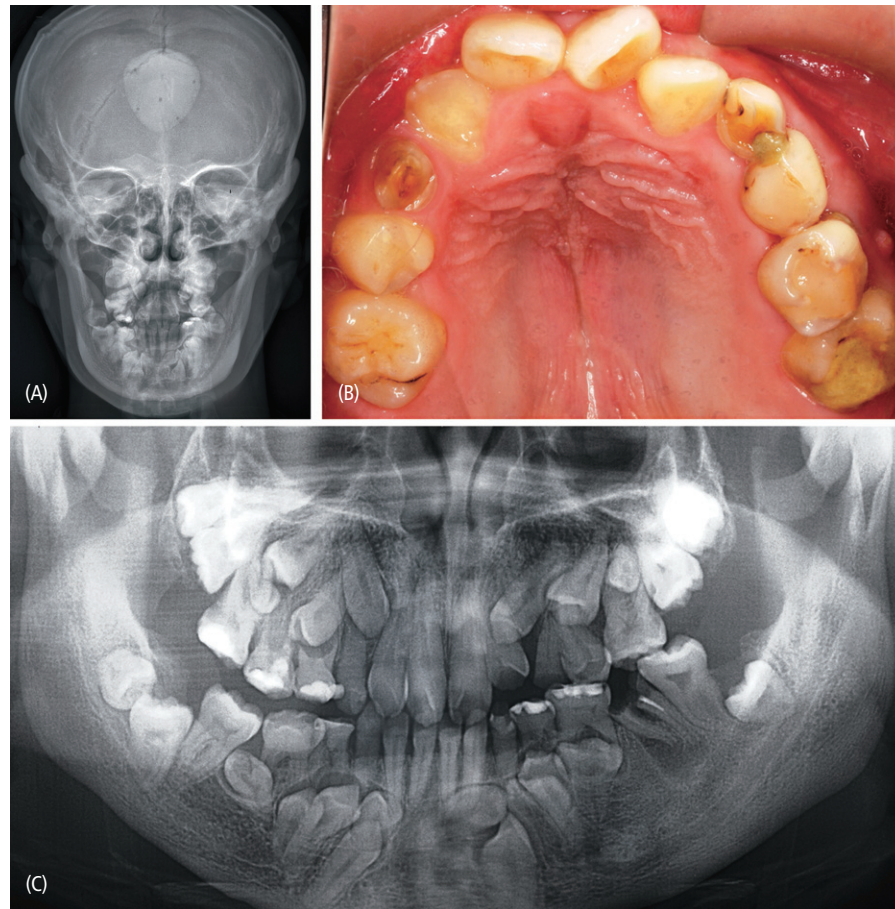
Analysis of the patient in Case 3 at 25 years of age. (A) Skull radiograph, (B) intraoral photograph, and (C) panoramic radiograph.
